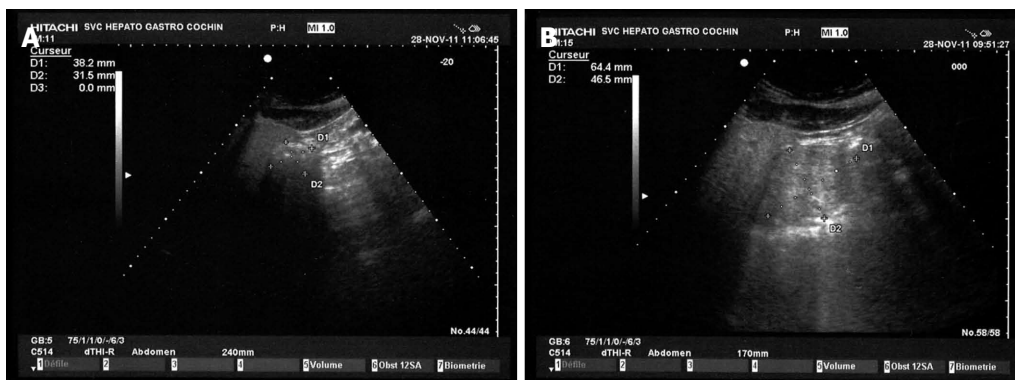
Measurement of the surface antral by ultrasonography in a patient in right lateral position at baseline. A: Measurement after 12 h of gastric rest; B: Measurement after the ingestion of 750 mL water plus 12 tablets of NaP in 45 min showing a distortion of the antrum. NaP: Sodium phosphate bowel preparation.
